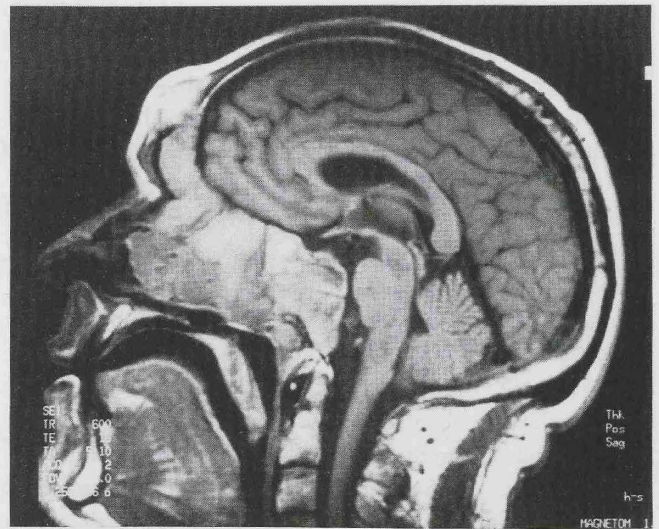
Case No. 2: Sagittal T<sub>1</sub>-weighted MR image (TR/TE 600/15) showing frontal sinus mucocele with destruction of the anterior sinus wall. Nasal and paranasal confluent polypoid masses posteriorly breaking through the clivus towards the brain stem.
